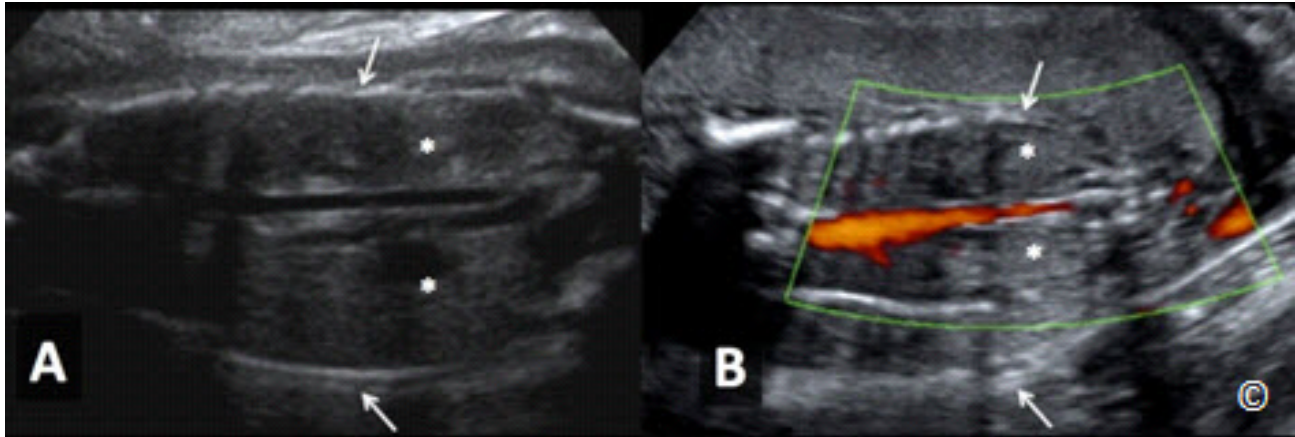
A and B: Coronal planes of the abdomen in 2D (A) and color Doppler (B) modes in a fetus with bilateral renal agenesis. Note the presence of anhydramnios (arrows) and absence of kidneys (asterisks) in the renal fossa. Note the absence of renal arteries on color Doppler (B).
